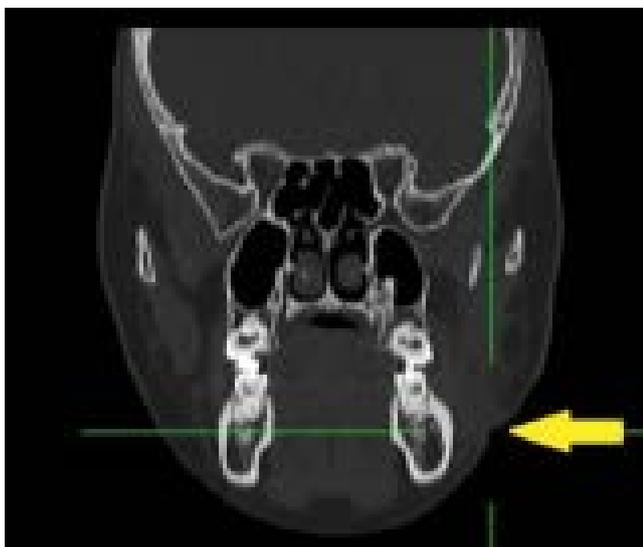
Computed tomography scan in coronal section shows crater-like skin retraction of the left cheek.
